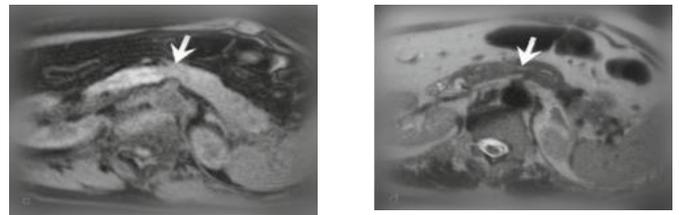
MRI images of Pancreas with Malignant tumor
